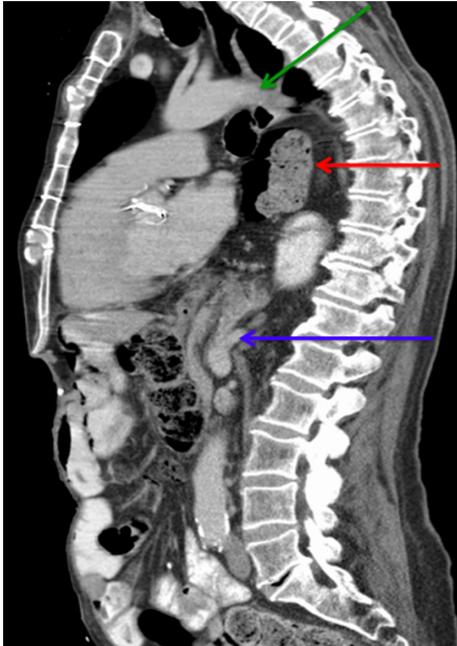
Sagittal CT scan: there is clear evidence of thoracic spine kyphosis. Green arrow – arch of aorta, red arrow – transverse colon, blue arrow – diaphragmatic defect.
